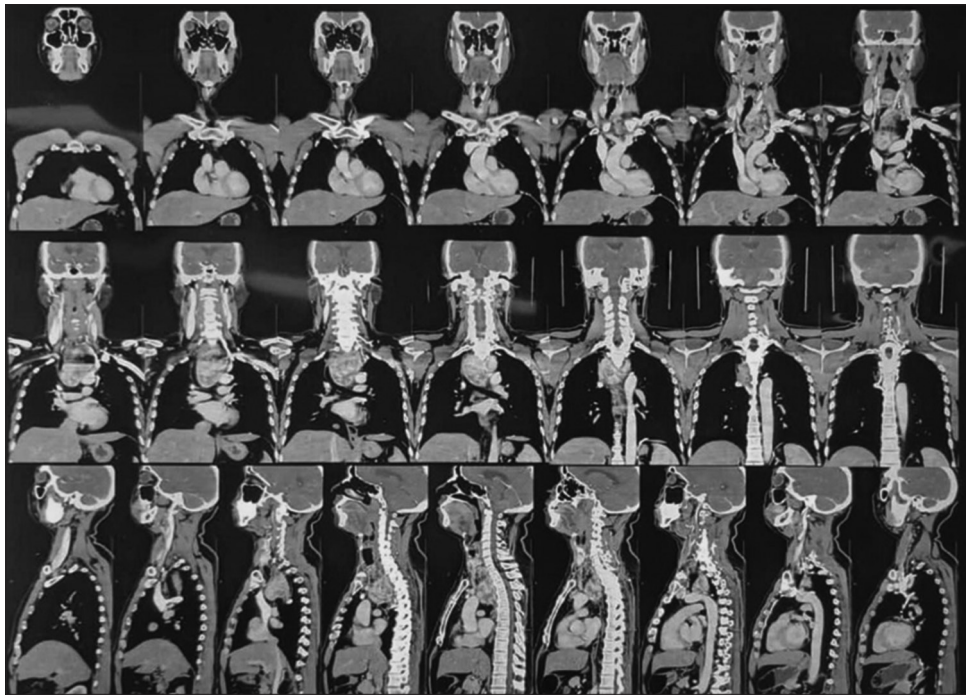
Contrast-enhanced sagittal and coronal computed tomography images of the neck and chest revealing a 9 cm cervico-mediastinal thyroid mass extending below the aortic arch, compressing the trachea with preserved surrounding fat planes
